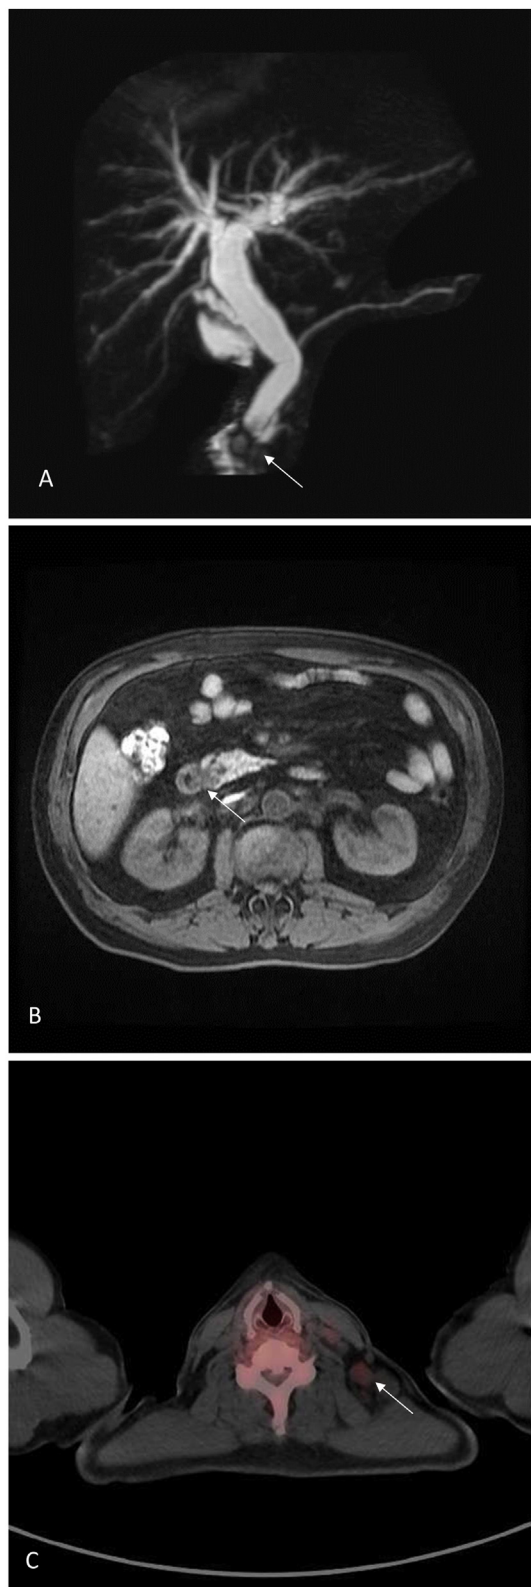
(A–B) A low signal intensity soft tissue mass (arrow) in the ampulla of Vater with dilatation of common bile duct as seen on MRCP. (C) P PET/CT showed FDG uptake metastatic lymph nodes over left neck (arrow).
